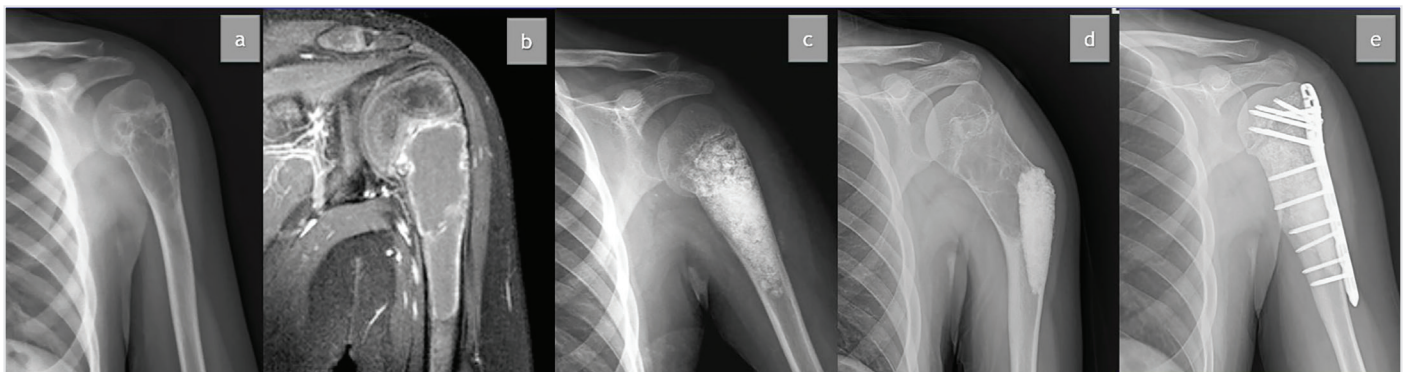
(a, b) A 10-year-old male patient was diagnosed with humerus SBC. (c) The patient was treated with curettage and grafting with bone glass graft (d) Recurrence and deformity are observed in the third postoperative year. (e) Follow-up radiograph of the patient after re-operation. SBC: Solitary bone cysts
